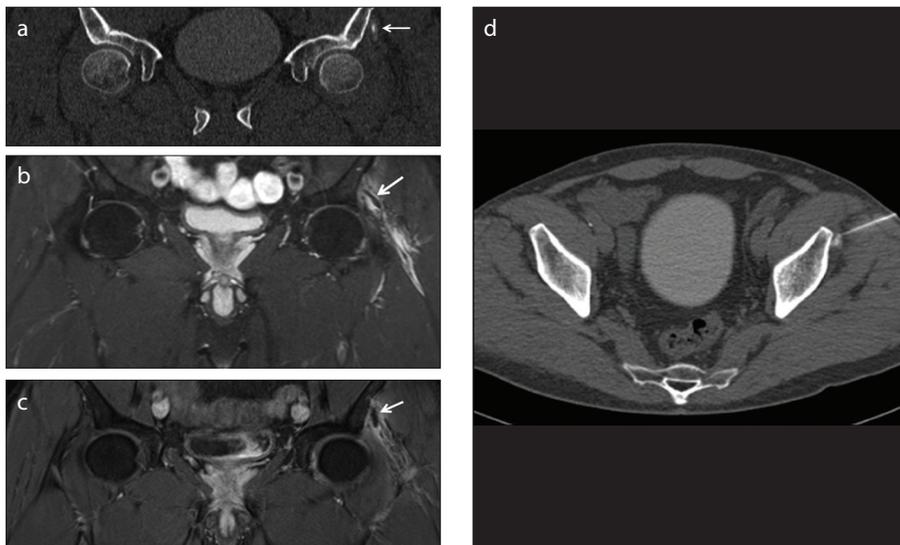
a–d. A 50-year-old male patient with unbearable left side pain, with no response to conservative treatment. The coronal CT reconstruction (a), STIR (b), and fat suppressed contrast-enhanced T1-weighted (c) images show the calcification within the gluteus minimus tendon, with surrounding soft tissue edema (arrow in a–c). Positioning of the needle under CT guidance is shown (d). The hyperdense bladder is the result of intravenous administration of gadolinium-DTPA contrast a few hours before the CT examination.
